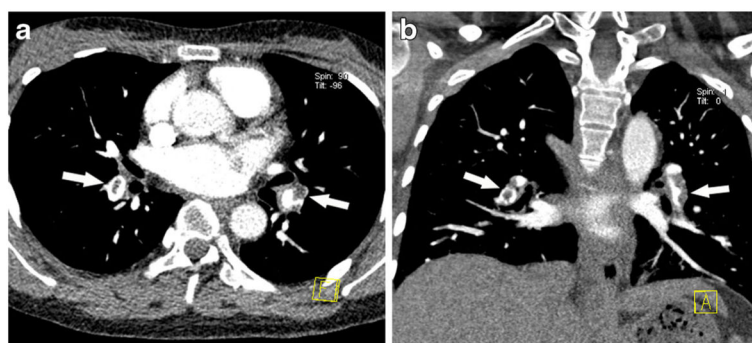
Partial filling defects of multiple pulmonary arteries in a 15-year-old girl with systemic lupus erythematosus. a–b Axial and coronal contrast-enhanced CT images demonstrate central filling defect in right pulmonary artery branch and eccentric partial filling defect in left pulmonary artery branch (*arrows*)
